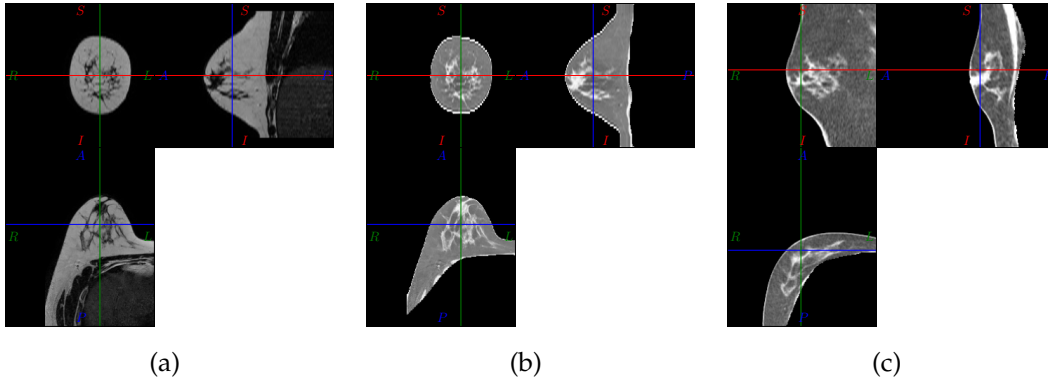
Intensity inversion of the prone T2 weighted MR image (a) is used to generate an image (b) which appears similar to a CT image (c) in terms of tissue contrast such that a mono modal image similarity measure and corresponding image forces can be used.*
